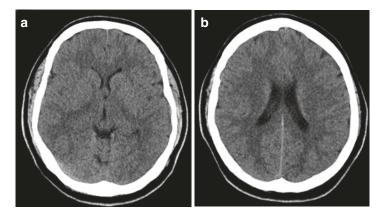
a) Normal non-contrast head CT at level of thalamus. b) Normal non-contrast head CT at level of lateral venticles
